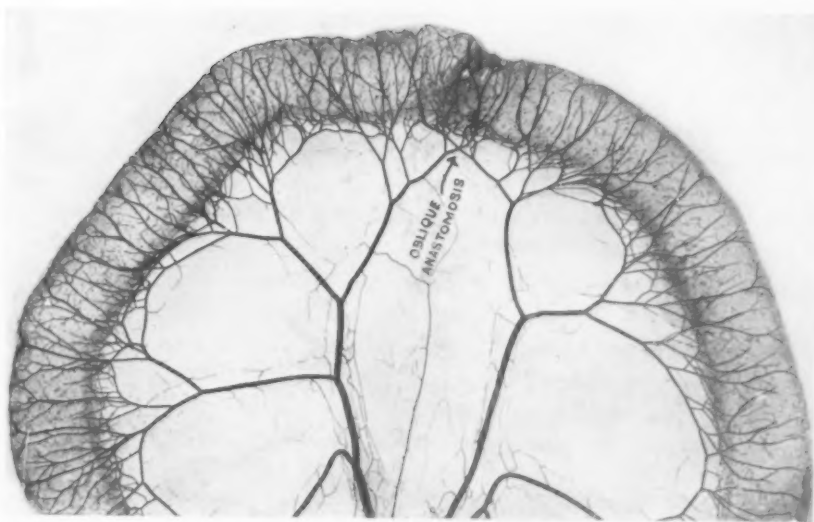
X-ray picture of circulation in a portion of intestine on which an anastomosis by the author's oblique method has been performed. Note that where the gut has been anastomosed the circulation is much more abundant than in any other portion of the intestine. The liberal supply of blood all along the line of anastomosis explains why the anastomosis made by the oblique method is much safer than the end-to-end.
